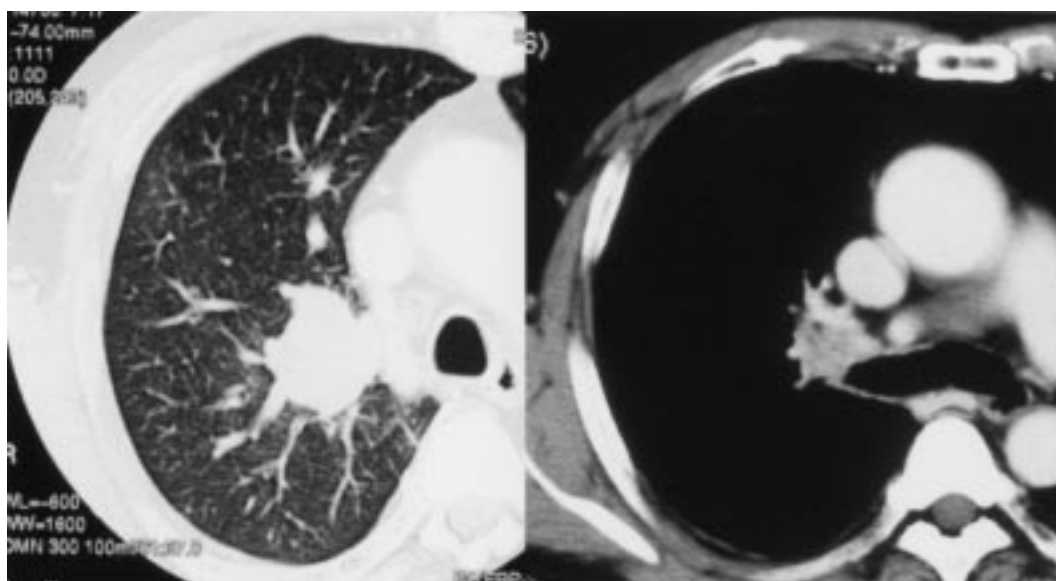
Chest CT showing an irregular mass shadow in the right upper lobe.
